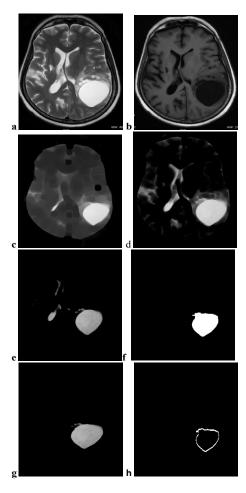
Shows the segmentation procedures for tumor and its boundary. a.T2-weighted image b. T1-FLAIR image c. Skull stripped image after erosion d. Subtracted image from dilated image and complemented image e. Thresholded image f. Binary tumor mask g. segmented grey level tumor h. Tumor boundary
